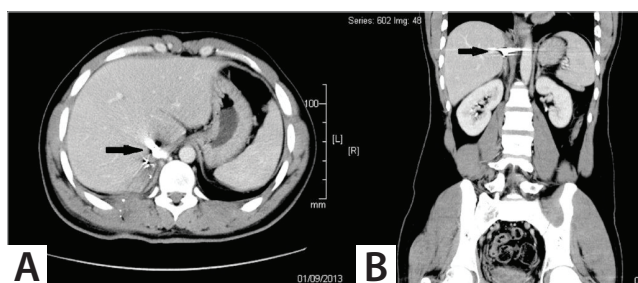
A. Axial and coronal B. Abdominal CT shows a gunshot bullet within the liver tissue.
